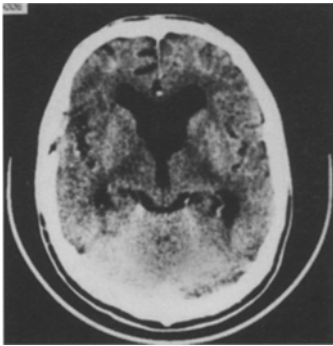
Axial CT scan shows no mass lesion and improved hydrocephalus 6 months after the operation.
